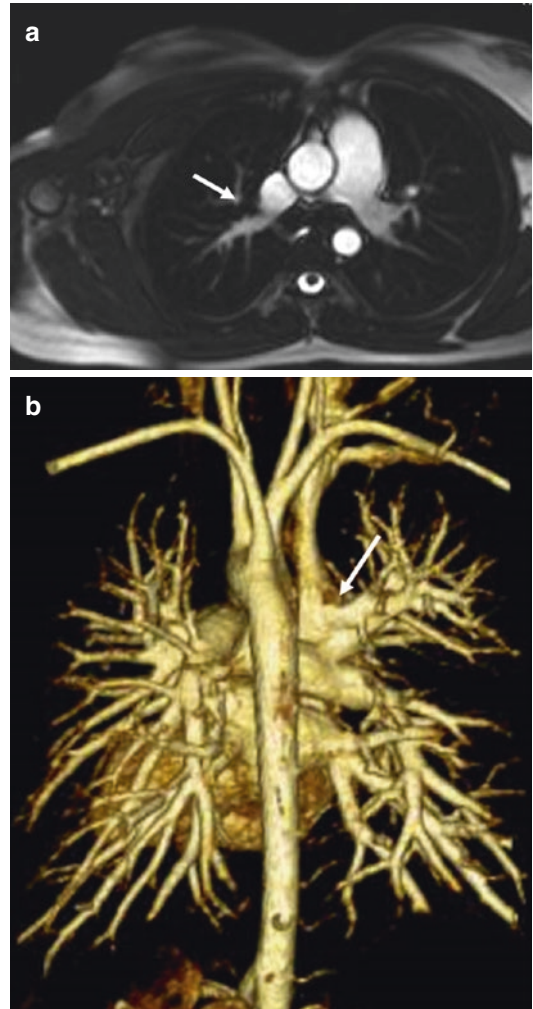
Right superior anomalous pulmonary venous return at cardiac MRI. (a) Axial view image obtained from cine FLASH MRI sequence and (b) posterior volume rendering image demonstrate an anomalous drainage of right superior pulmonary vein into the right superior vena cava (white arrows)
